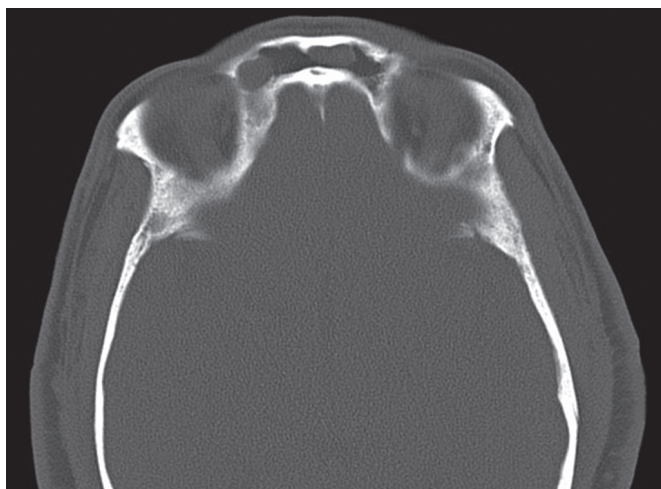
Axial CT demonstrating multiple mucocoeles.
